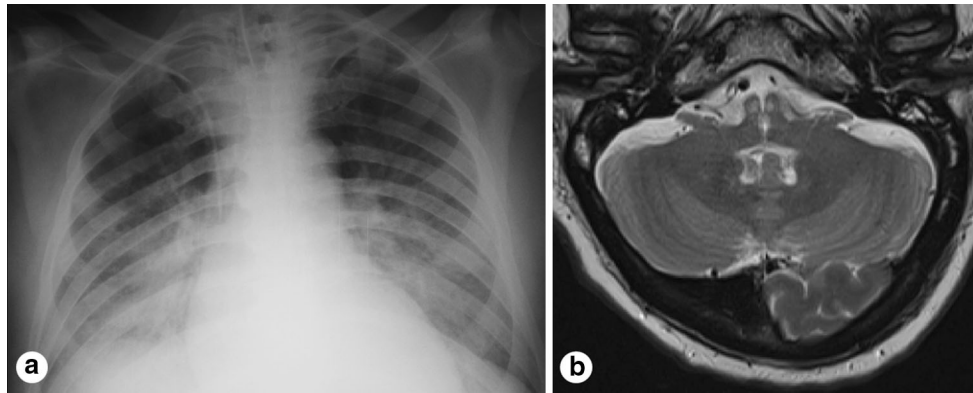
a Anteroposterior chest radiograph presented bilateral alveolar opacities indicating the existence of pulmonary edema. b Axial T2-weighted MRI demonstrated a “heart-shaped” hyperintense signal in the bilateral medial medulla along with tissue loss
